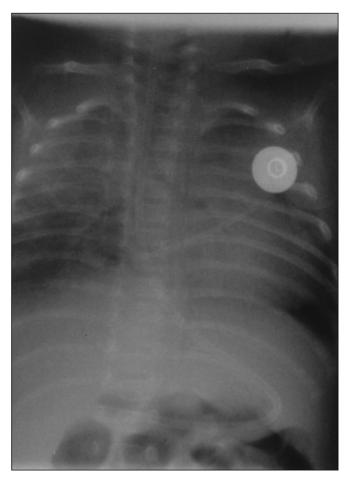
Chest X-ray showing the fragment of the catheter in the heart (Case 3).
